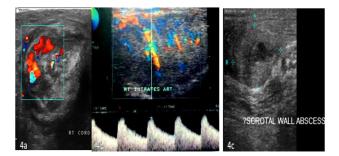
Epididymo-orchitis and abscess; (a) Grey scale sonography shows hypo echoic enlarged thickened right cord on Doppler diffuse hyper vascularity of the cord noted; (b) Spectral analysis of the case shows increased PSV (48.2/sec) and reduced RI (0.52) suggestive of high flow with impedence. (c) Grey scale sonography shows Scrotal wall appears thickened and shows an abscess measuring 2.3 x 1.9 cm.
